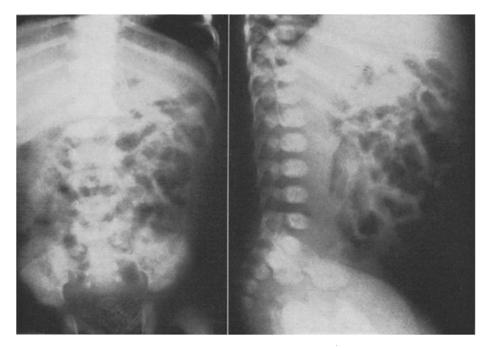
Same case as Fig. 1a. The X-ray appearances immediately after saline cleansing washouts had been given
